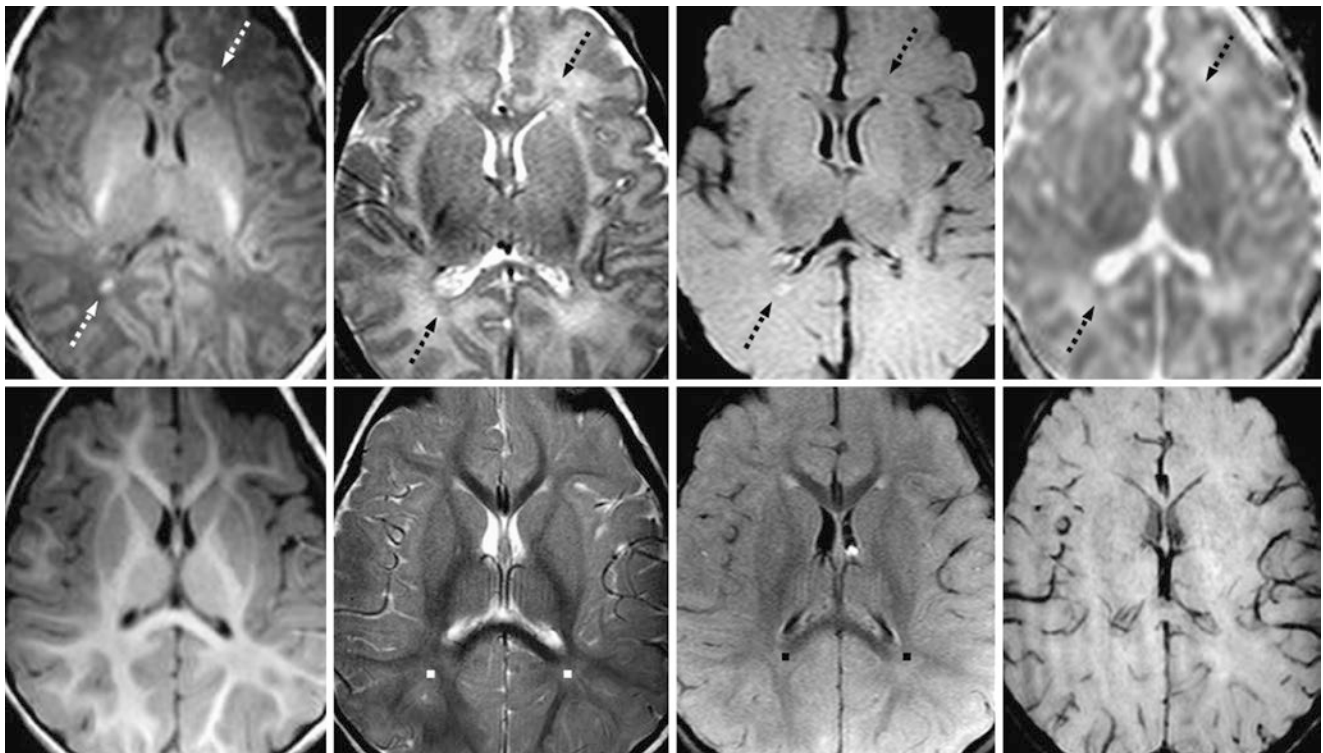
Comparison case of noncavitary white matter injury. *Top row:* A 7-day-old term infant with respiratory difficulty had a 3T MRI that showed bright foci of WM injury (*dotted arrows*) on GE T1WI (*left*), which were isointense on T2WI (*left middle*) and FLAIR (*right middle*) and slightly dark on an ADC map (*right, normal DWI*). *Bottom*
